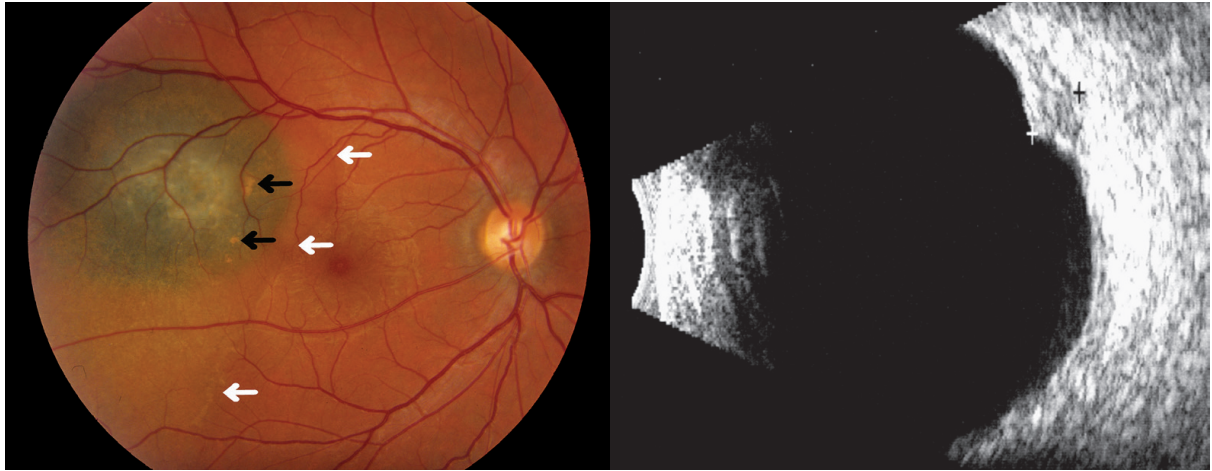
A small choroidal melanocytic tumour with 4 clinical risk factors: symptoms (metamorphopsia and a visual field defect), on ophthalmoscopy (Left): subretinal fluid (SRF) (white arrows), and orange pigment (OP) (black arrows), and on B-scan ultrasonography (Right): a tumour thickness over 2 mm, as well as a relatively hollow internal reflectivity.
